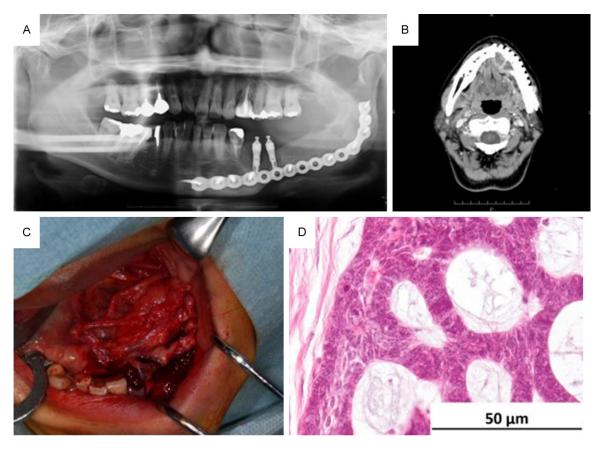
Clinical and pathologic findings at recurrence. (A, B) Panoramic radiograph (A) and contrast-enhanced computed tomography (B) revealed a well-circumscribed multilocular mass that occurred centrally in the mandible from the left mandibular lateral incisor to the left mandibular molar. (C) The lesion was clearly identified by an intraoral approach. (D) The lesions were composed of basal cell-like cells against a background of fibrous tissue, with glandular duct-like or reticular structures and solid proliferation (Magnification ×400).
